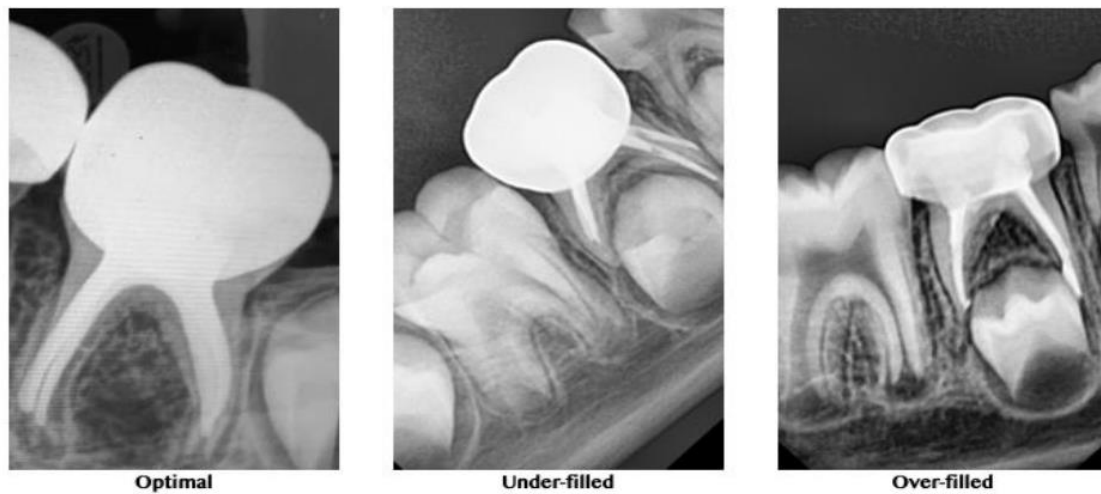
Representative radiographs for the quality of obturation.
